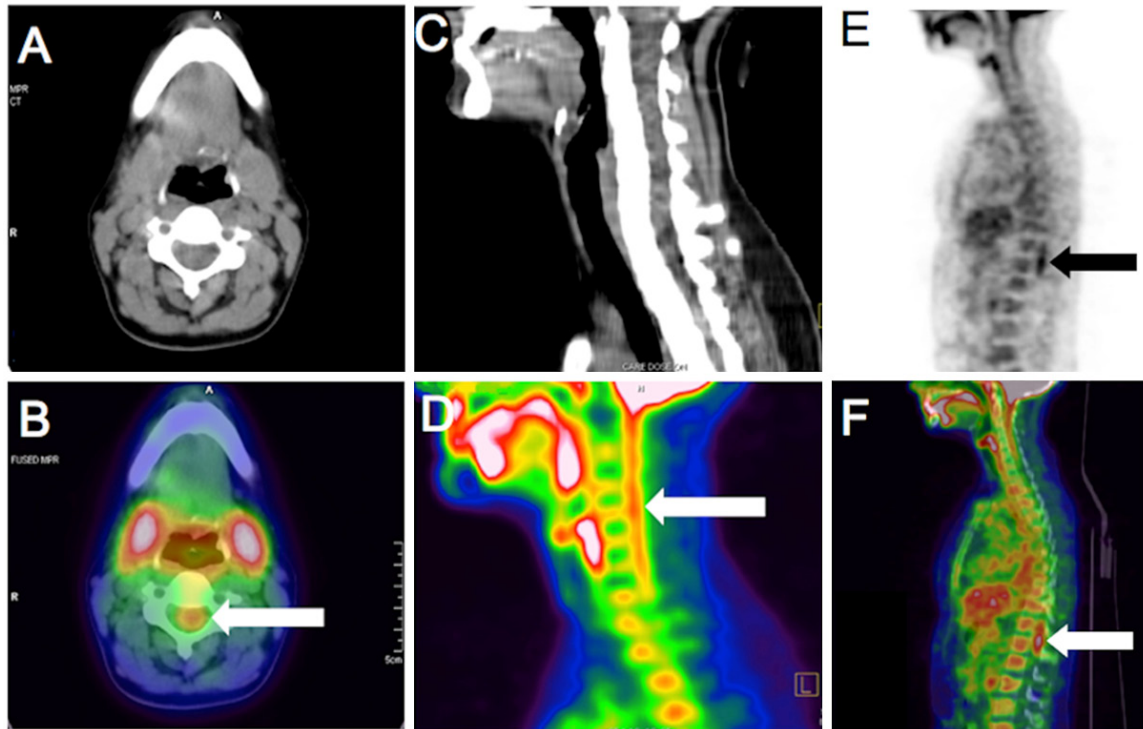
A 33 year-old physically active female with ovarian cancer treated with surgery and chemotherapy underwent a repeat ^{18}F FDG PET-CT scan after 83 minutes of ^{18}F FDG injection as part of her follow up work-up. The Liver SUV_{max} was 2.7 and Liver SUV_{avg} 2.1. Her C-spine $\text{SUV}_{\text{max/avg}}$ were 3.0/2.6, T11-T12 spine $\text{SUV}_{\text{max/avg}}$ were 3.5/2.9. PET-CT scan did not reveal any signs of malignancy. The enhanced ^{18}F FDG activity along the cervical spinal cord is seen as depicted by arrow in fused transverse PET-CT image (B), and in sagittal view (D). Corresponding CT images are depicted in Figure 2A and 2C. The focal increased ^{18}F FDG activity in T11-T12 segment thoracic spinal cord is depicted by the arrow in a sagittal PET image (E), and in a fused sagittal PET-CT image (F), which was classified as a normal variant in this asymptomatic patient.
